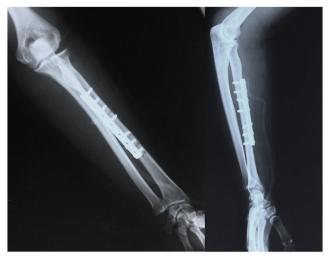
Post-operative plain radiographs: Radial shaft managed by open reduction and internal fixation using an anterior dynamic compression plate. The radial head and the distal radio-ulnar joint are reduced
